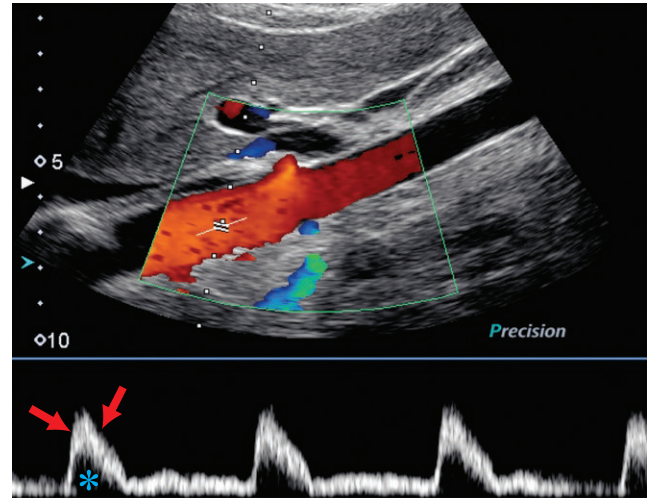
Spectral Doppler of the abdominal aorta shows normal absent spectral broadening. There is no spectral broadening in the aorta because the flow profile is plug. In plug flow, the fastest velocity is present in most of the width of the vessel and blood slows down abruptly only near to the vessel wall. The envelope is well defined and there is not filling of the spectral window in systole (*) since all of the blood in the sample volume is flowing at the same velocity and direction. Velocity does slow down near the vessel wall but this is not in the sample volume.
